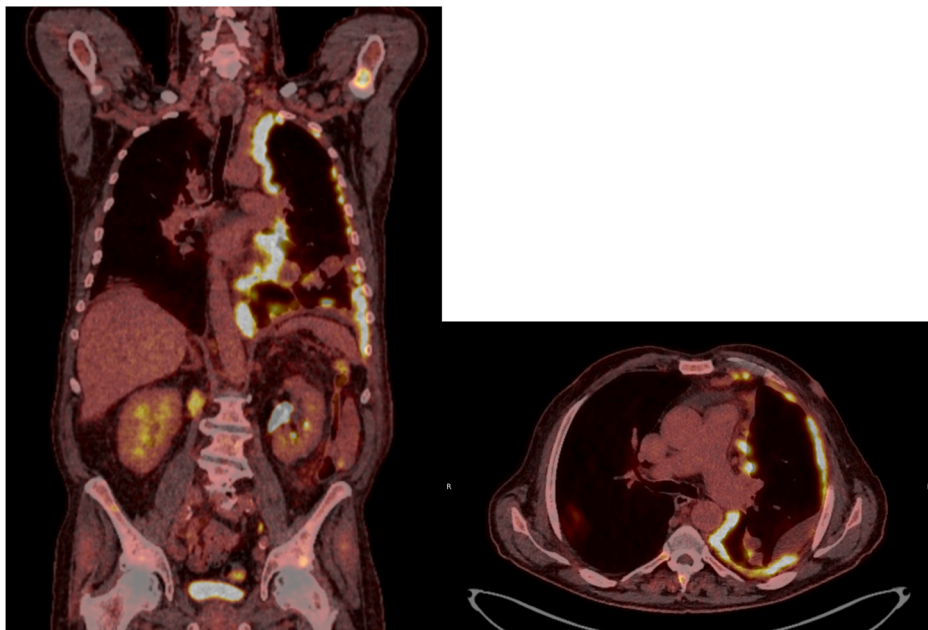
PET-CT showing increased uptake in the left pleura, in multiple pathological lymph nodes over and under the diaphragm and in the skeleton.
